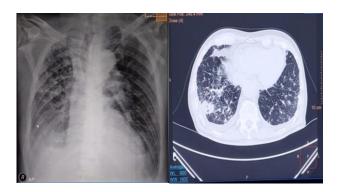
Chest X-ray reveal infiltrate and pleural effusion of the right lung. Chest CT-scan show lung tumor in the right inferior pulmonary lobe.
